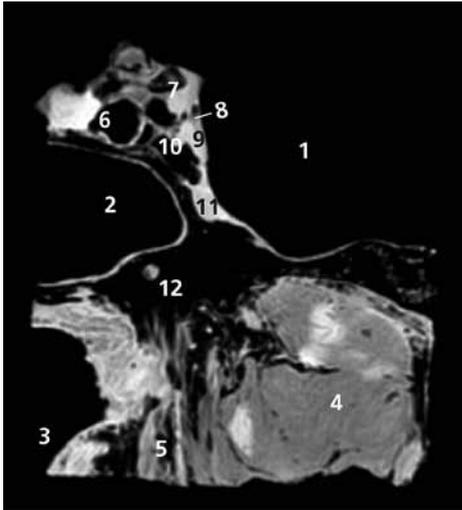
Coronal MR image of left cavernous sinus
